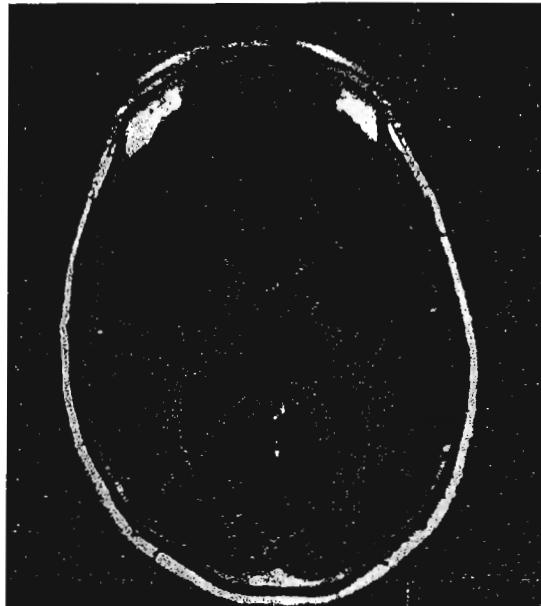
Horizontal (axial) magnetic resonance image of the living brain.
